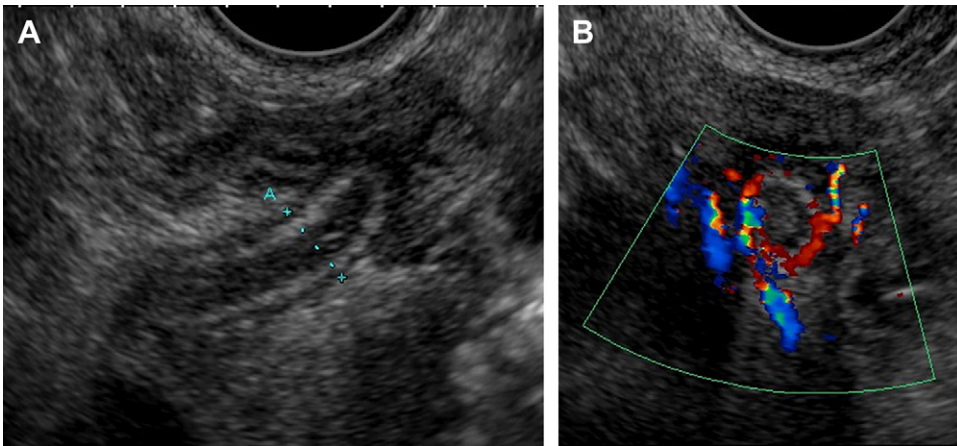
(A) Abnormal appendix identified only transvaginally, measuring 8 mm. (B) Presence of increased Doppler signal supporting the diagnosis of appendicitis.
